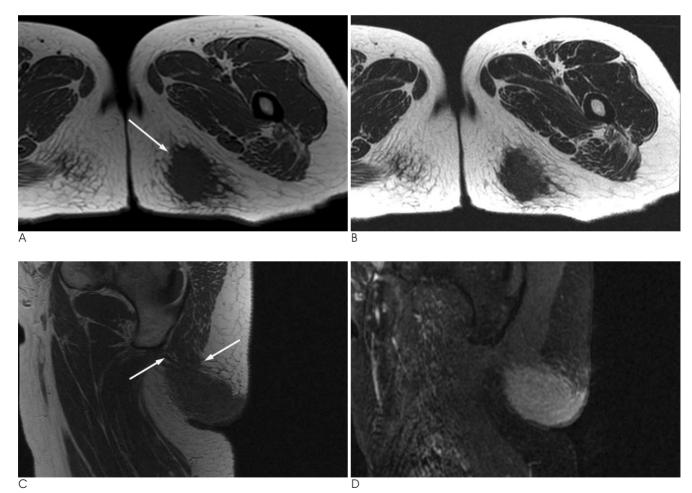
A. An axial T1-weighted spin echo MR image (TR/TE: 650/9) shows a subcutaneous mass (arrow) with a spiculated border. The mass appears isointense relative to the adjacent muscle.
